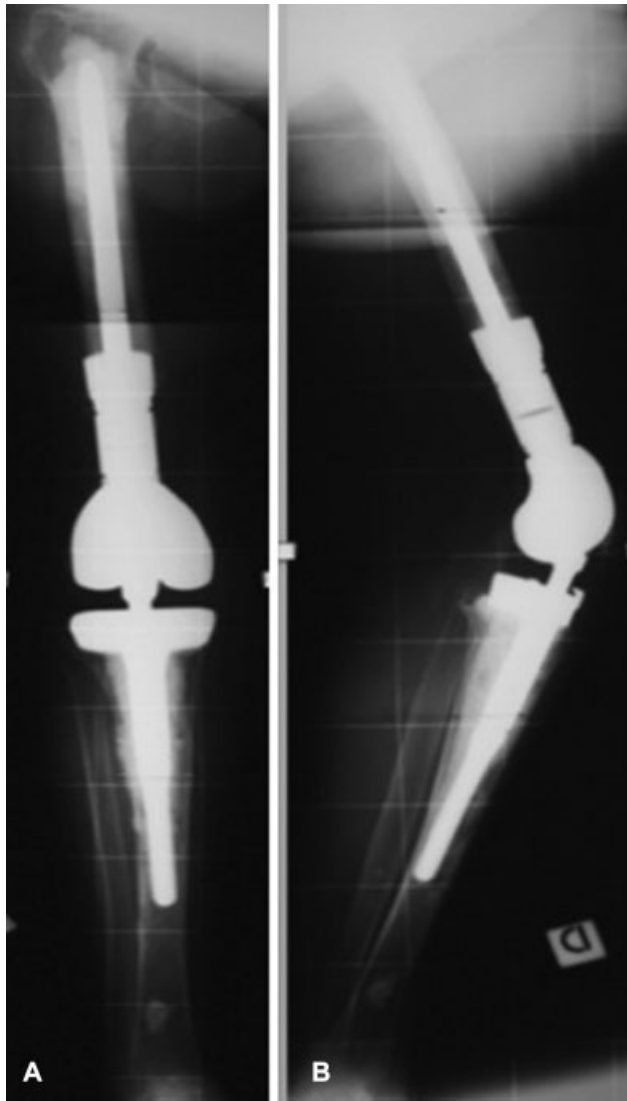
Postoperative anteroposterior (A) and lateral (B) radiographs showing a tumor-like total knee arthroplasty (ZSS “Zimmer Segmental System,” Zimmer, Warsaw, Indiana, United States).
